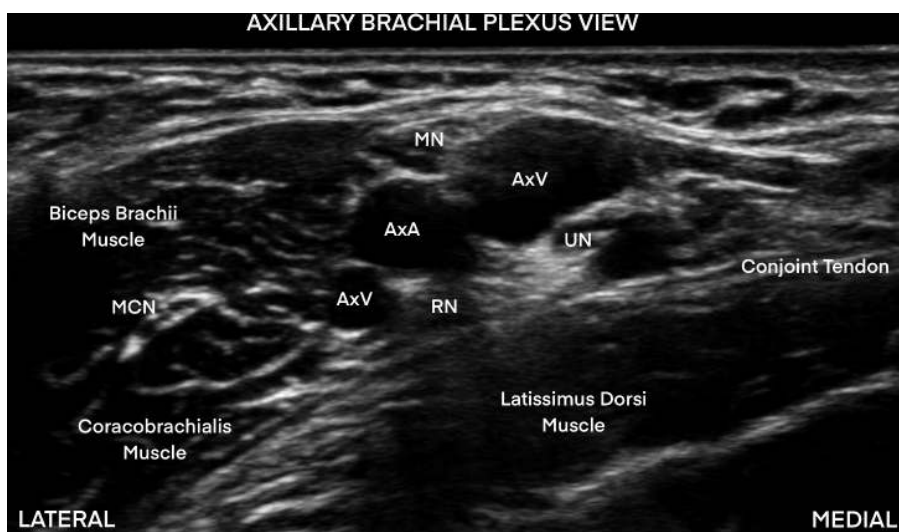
Ultrasound image of the brachial plexus at the location for the axillary block. The axillary artery (AxA) is surrounded by the ulnar (UN), median (MN), and radial (RN) nerves. The musculocutaneous nerve (MCN) is seen laterally within the coracobrachialis muscle. Also seen is the axillary vein (AxV).
